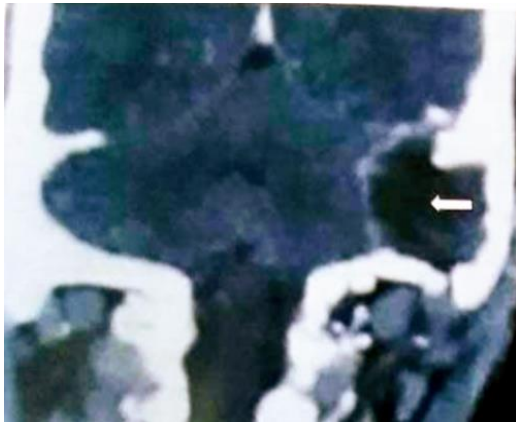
Coronal CT with contrast demonstrating mastoiditis with abscess collection in right sternocleidomastoid (Bezolds abscess).
